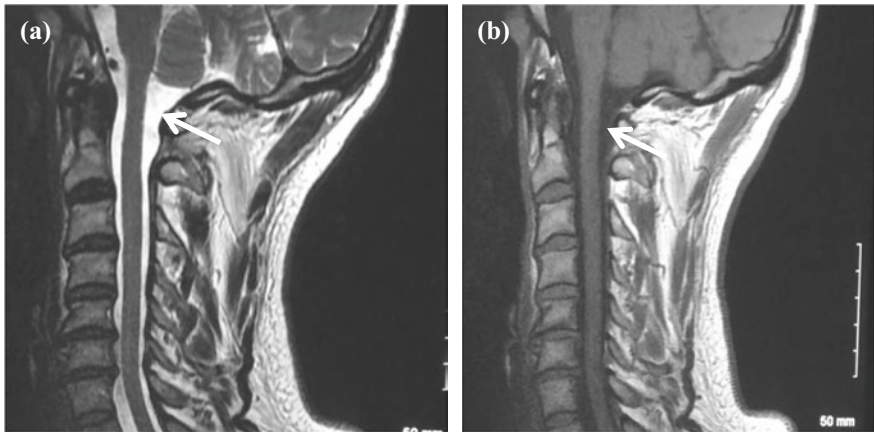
MRI sagittal images of the cervical spine. The white arrows demonstrating the differences in the signal intensity of the cerebrospinal fluid in the spinal canal. This fluid is bright in image a (T2 weighted) and dark in image b (T1 weighted)
